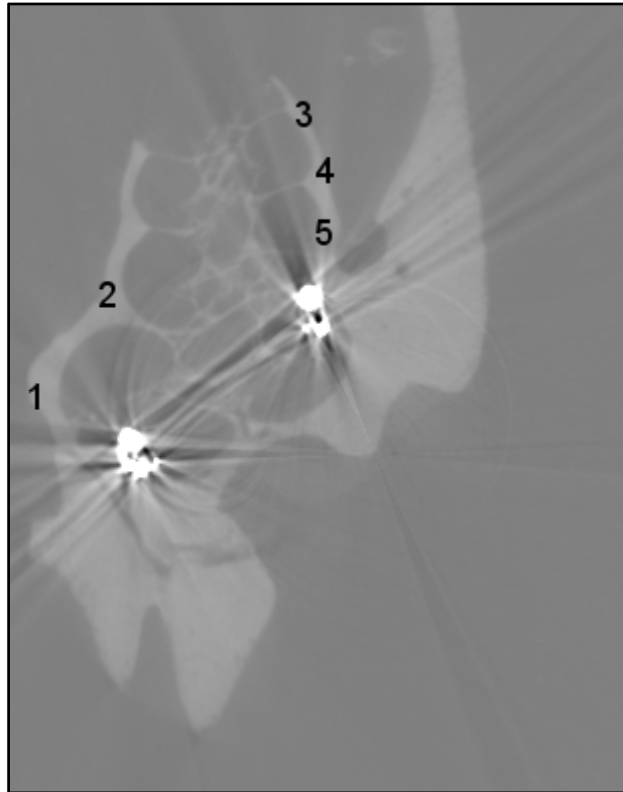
CT slice of the cochlea supplied by Bonham et al.
